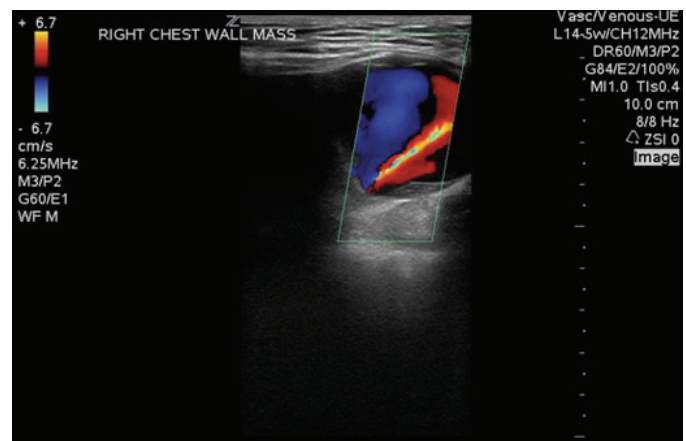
Color flow Doppler ultrasound of the chest wall mass identifying a pseudoaneurysm.
